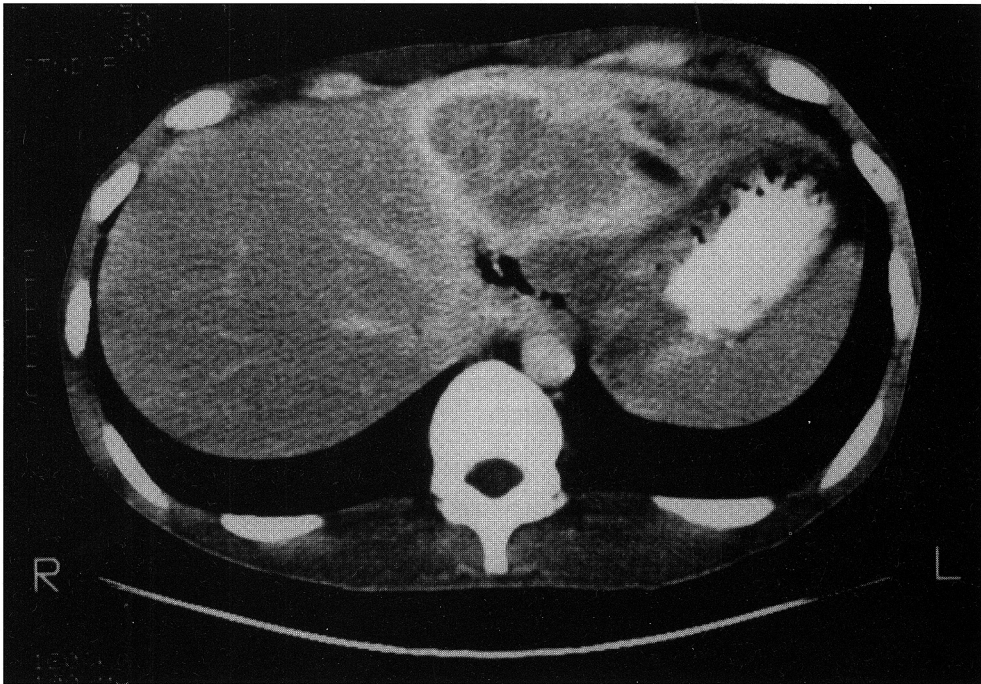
The CT scan demonstrating a huge abscess with ring enhancement in the left lobe of the liver.
